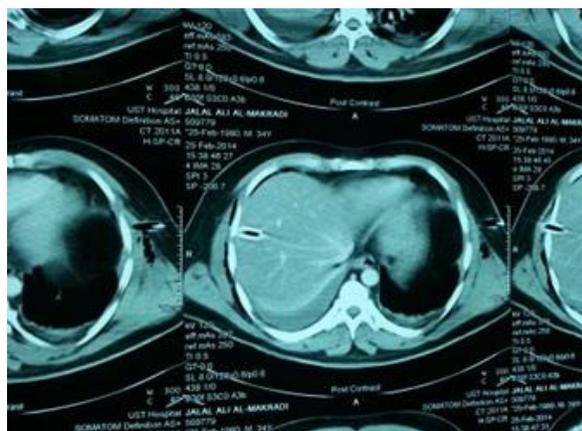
thoracoabdominal CT scan for adult male post RTA patient with mild pneumothorax did for him thoracostomy wrongly inserted to the liver parenchyma.
